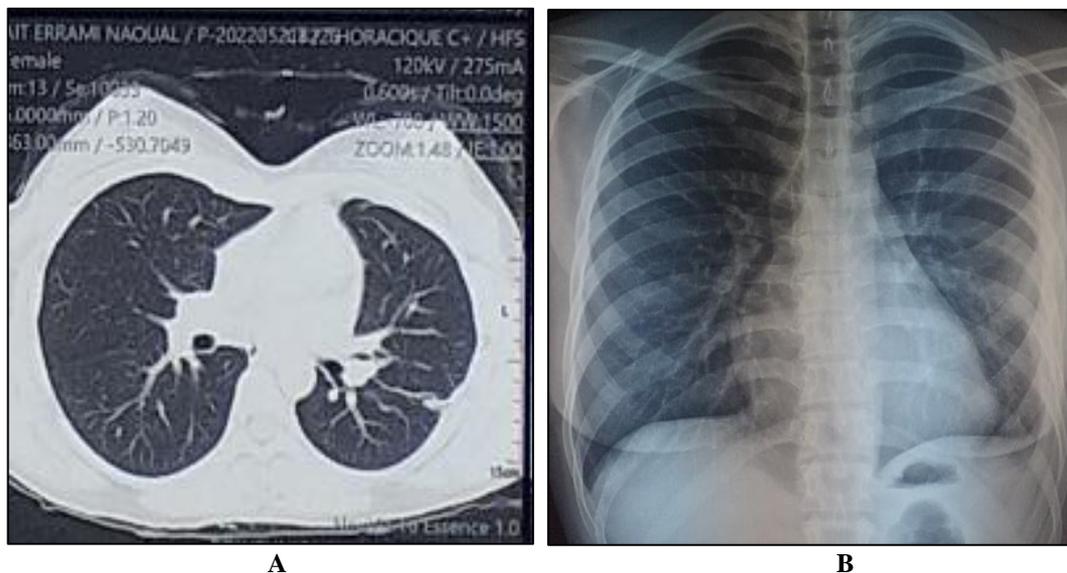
Chest imaging (A: X-ray; B: CT scan) showing disappearance of left pneumothorax after 6 months of antifungal treatment
